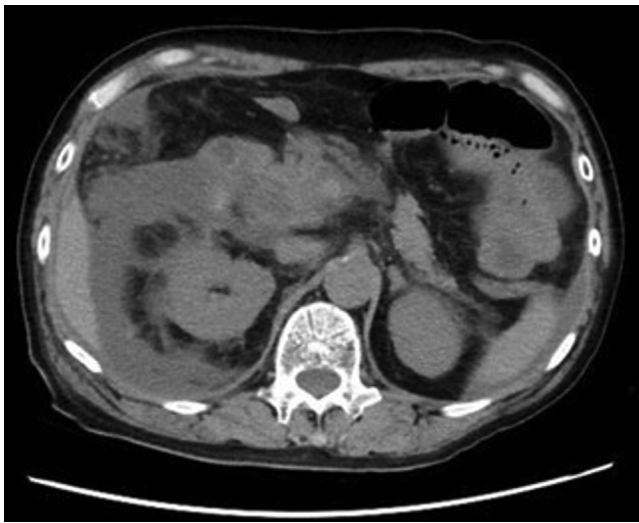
CT scan performed 1 day after ERCP did not detect the perforation; however, post-ERCP pancreatitis developed.
